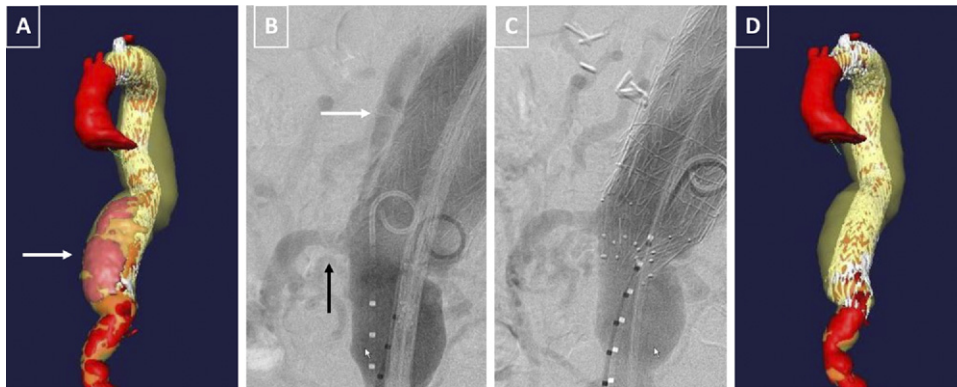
A, A computed tomography angiogram reconstruction using M2S software (West Lebanon, NH) shows a distal type I endoleak (arrow) after the initial thoracic endovascular aneurysm repair, including celiac artery coverage. B, Antegrade superior mesenteric artery perfusion (black arrow) is evident in this angiogram, which also demonstrates a distal type I endoleak (white arrow) in the patient from Panel A. C, An angiogram shows distal sealing and aneurysmal exclusion after reintervention. D, An M2S reconstruction of a postreintervention computed tomography angiogram note the absence of endoleak.
